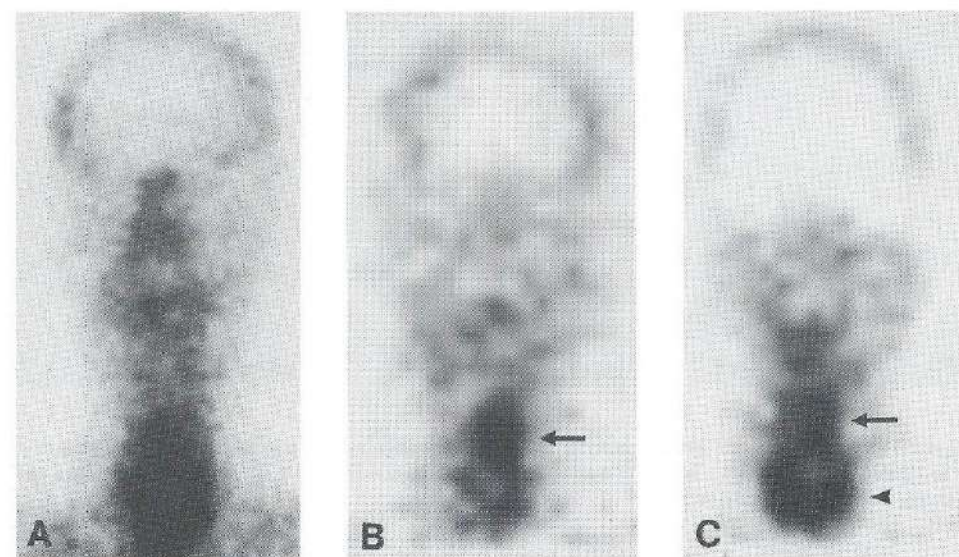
(A) Planar anterior image of the head and neck of patient 2, 16 h after injection of <sup>99m</sup>Tc-labeled 323/A3 F(ab')<sub>2</sub>. Increased uptake is seen in the laryngeal area. (B) Coronal SPECT images of the same patient show the primary laryngeal tumor (arrow) and (C) more anteriorly the thyroid gland (arrowhead).
